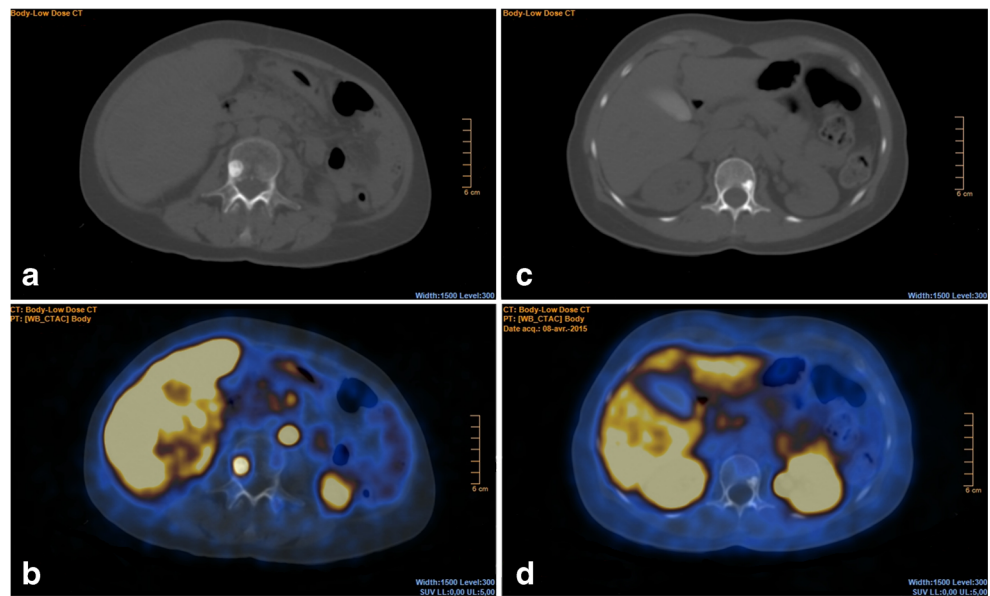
Axial CT and fusion images. An osteoblastic vertebral metastasis of L3 in a 57-year-old woman referred for restaging of a lung neuroendocrine tumour (NET) showed an intense DOTA-TOC uptake ($SUV_{max}=11.0$, SUV_{max} ratio to reference vertebra=23.9, to liver=2.20, to spleen=0.72) (A and B). An osteoblastic bone island of L1 in a 54-year-old woman referred for characterization of a pancreatic lesion showed no significant DOTA-TOC uptake (C and D)
